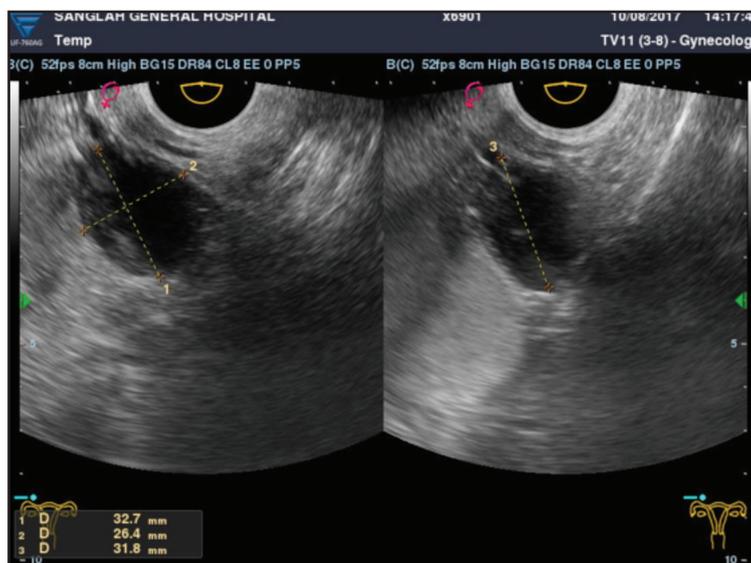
The picture from rectal sonography reveals a cystic lesion from the left adnexa with 3.2x2.64 cm dimensions on the longitudinal plane (left) and 3.18 cm dimension on the transversal plane (right). US performed using GE Logiq V5.
